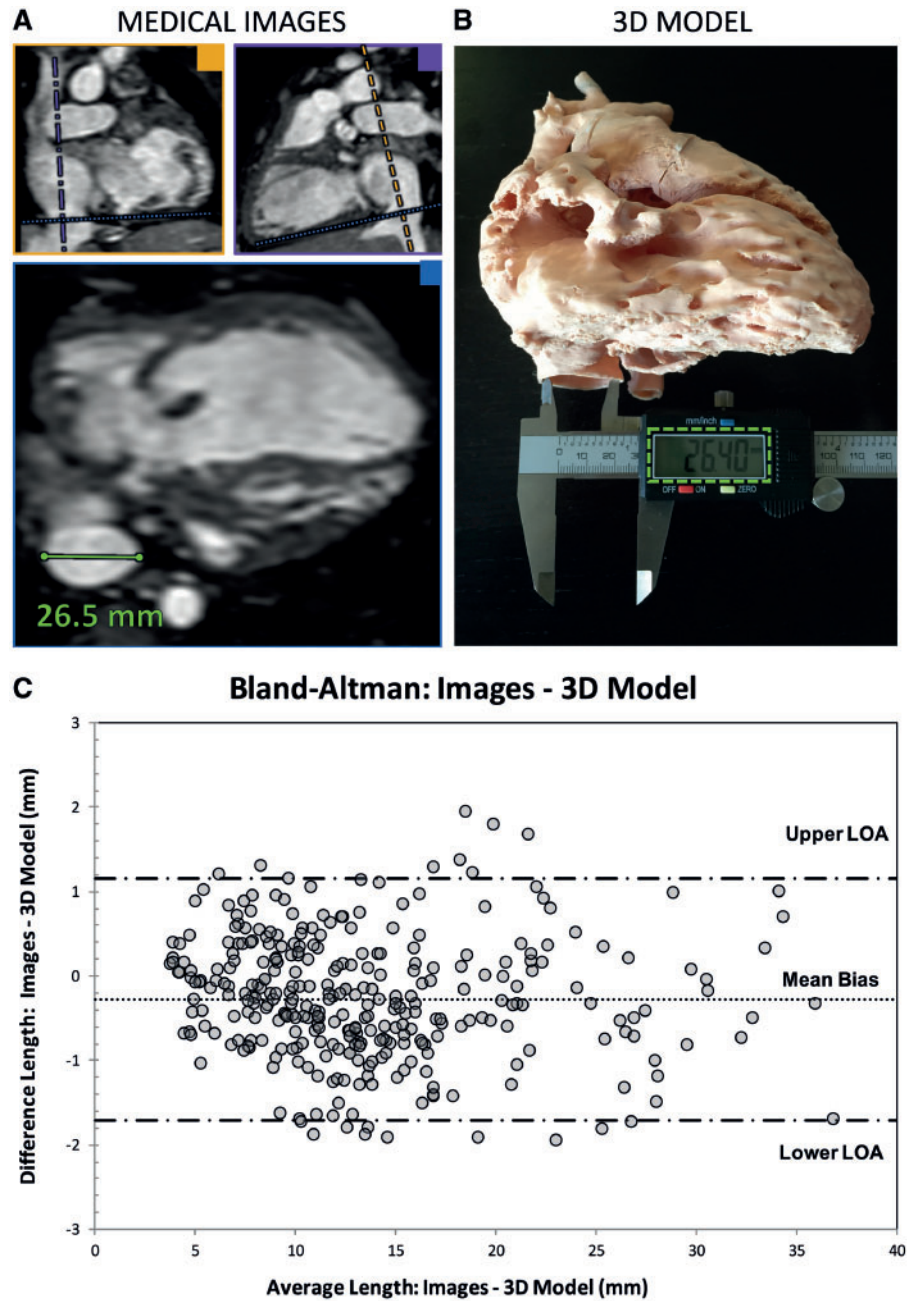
3D model dimension accuracy evaluation. (A) Multiplanar reformat of medical images (MRI 3Dbssfp) in coronal (orange box) and sagittal view (purple box) to obtain a cross-sectional plane (blue box) to measure the inferior vena cava. (B) Measurement of the inferior vena cava in the 3D model in the same orientation as in A using a digital caliper. (C) Bland-Altman plot measurement agreements between medical images (magnetic resonance imaging/computed tomography) and 3D models. LOA: limits of agreement, ± 2 SDs. Values expressed as millimetre.
